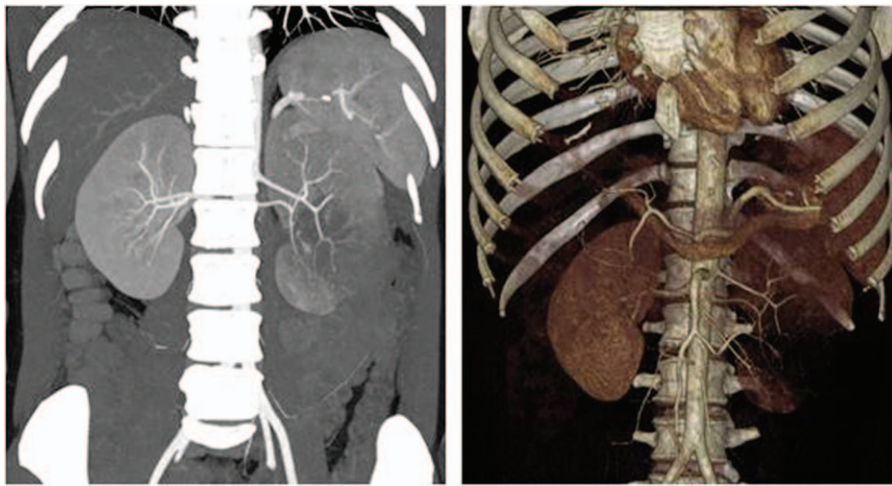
CT angiography does not reveal any tumor feeding vessels or vascular malformation. CT=computed tomography.
